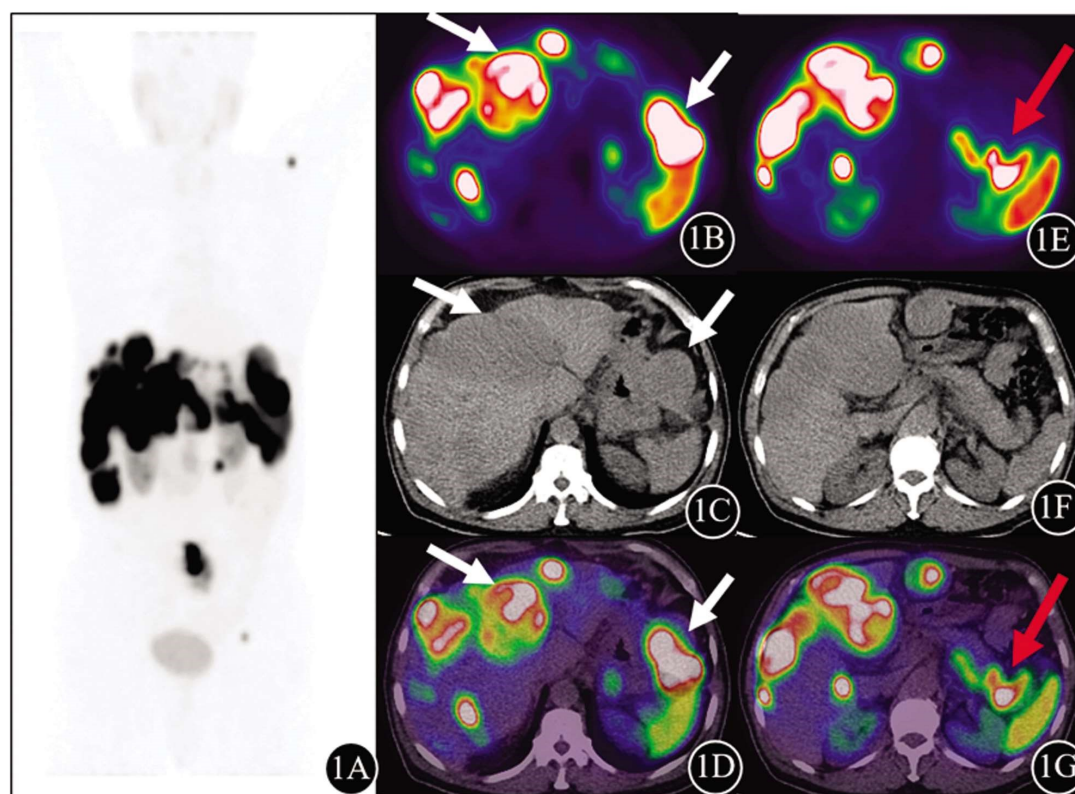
因上腹部不适行“肝占位”穿刺活检示神经内分泌瘤(G1级: Ki-67+, 约 2%)患者(男, 59 岁) ^{68}Ga -DOTANOC PET/CT 显像图。PET(1B)及 PET/CT(1D)示: 肝脏、脾 - 胃间隙多发结节状 ^{68}Ga -DOTANOC 摄取增高灶(白箭头示), SUV_{max} 介于 9.9-27.5; PET(1E)及 PET/CT(1G)示: 胰尾部 ^{68}Ga -DOTANOC 结节状异常摄取灶(红箭头示), 大小约 $4.3\times 3.6\times 3.6\text{ cm}$, SUV_{max} 44.7, 后经超声内镜及穿刺活检证实为原发灶
